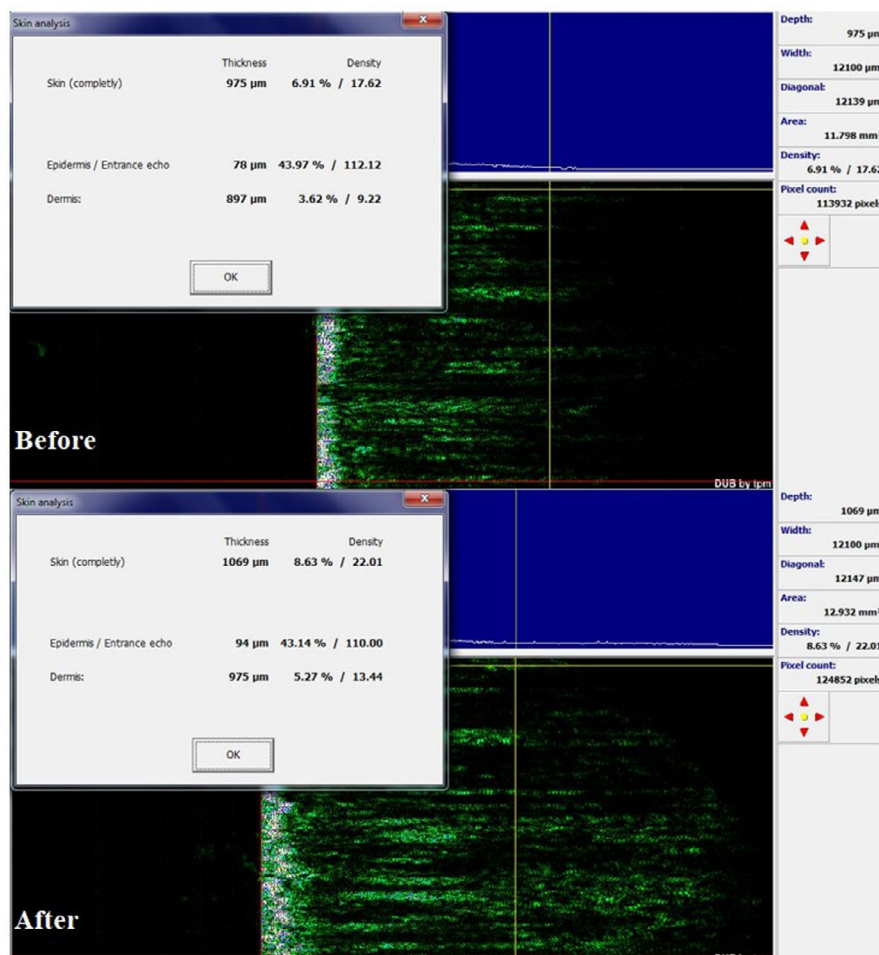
Skin analysis with ultrasonography Before and After treatment. Increase in skin density, epidermal density and dermal density after 6 months was seen
